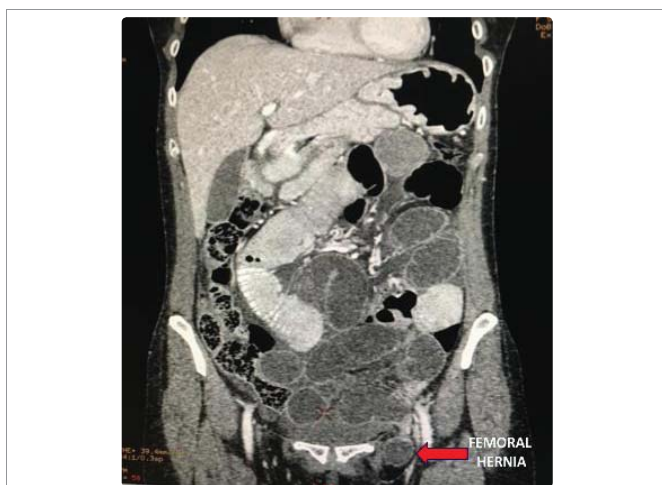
CT showing left femoral hernia and intestinal obstruction.
